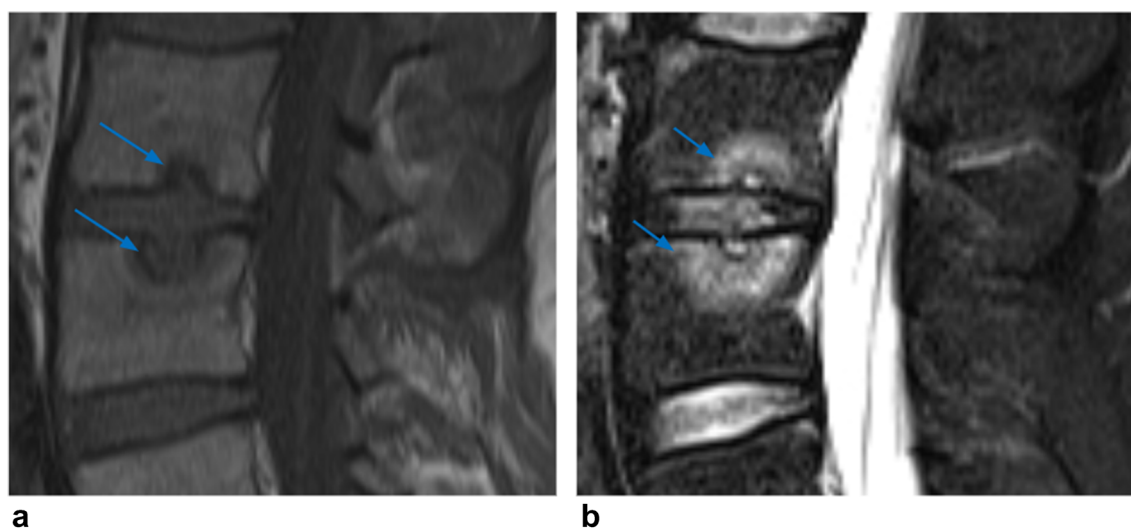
A 41-year-old man with psoriatic arthritis. a, b Sagittal T1-weighted (a) and STIR (b) MR images of the lumbar spine demonstrate bone erosions (arrows) with adjacent bone marrow edema (short arrows) on vertebral endplates related to inflammatory lesions
